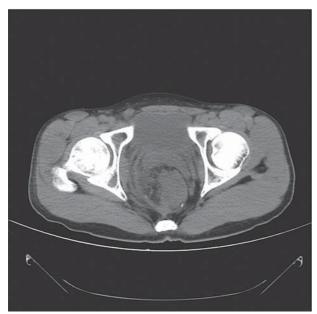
Computed tomography of the pelvis demonstrates a lobulated heterogeneous soft-tissue mass 5 cm in diameter over the left anterior wall of the anorectum with a few small soft tissue nodules over the adjacent mesorectum.
